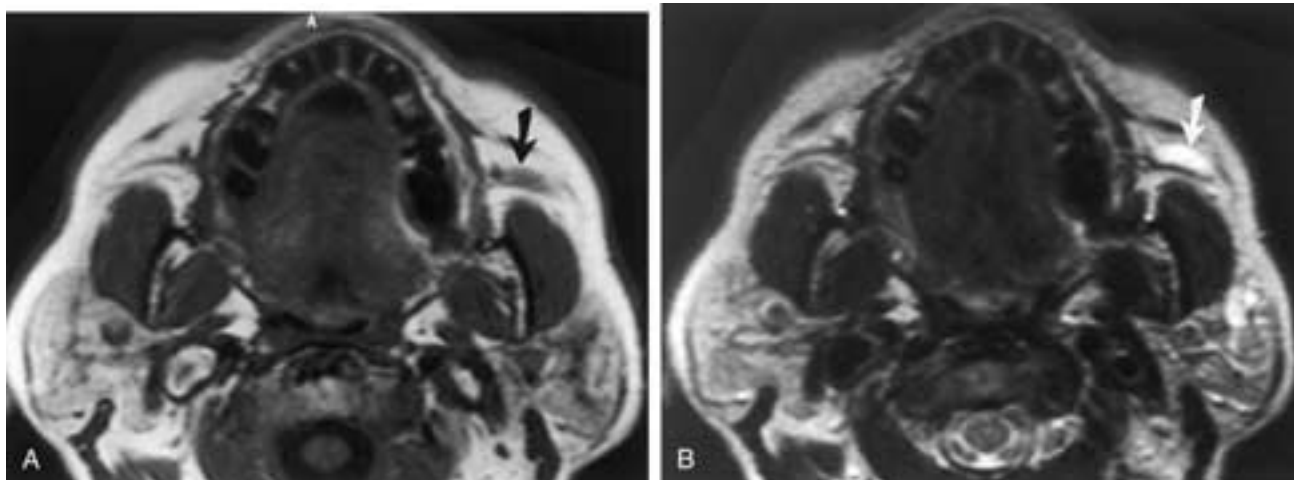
Dilated left parotid duct in the left buccal space. (A) Axial T1-weighted and (B) axial T2-weighted MR images demonstrate marked dilatation of the left parotid duct, hypointense on A and hyperintense on B, compatible with fluid (arrows). Only portions of the duct are visible on these images. There is also ductal dilatation within the left parotid gland best seen in (B).
